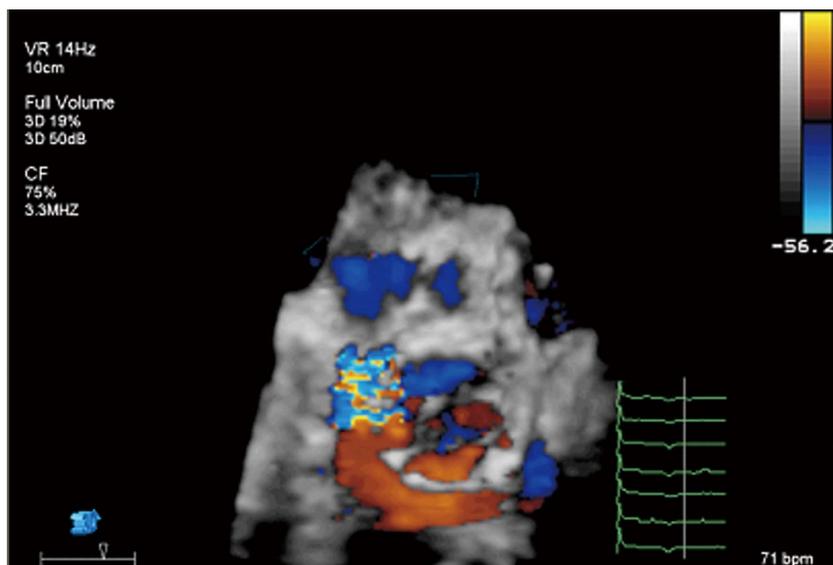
Transesophageal echocardiography 3D full volume showing the exact position of an important paravalvular leak.
